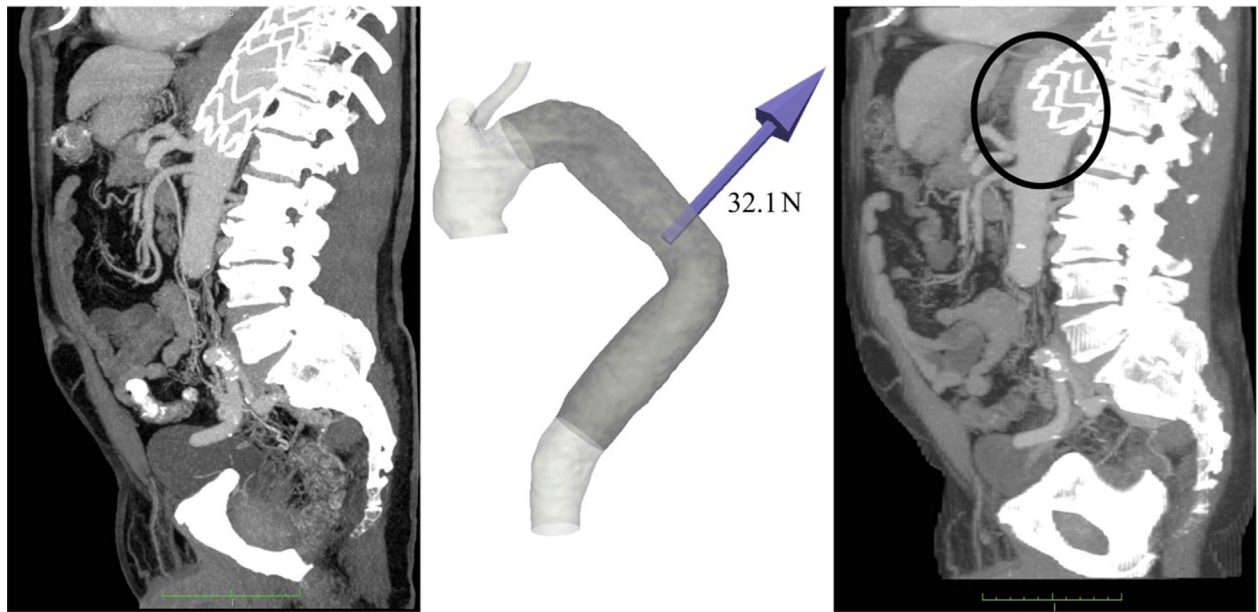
Displacement force and type 1b endoleak at 1-year follow-up. (Left) 1-month postoperative computed tomography angiography scan. (Middle) Postoperative computational fluid dynamic model with calculated
